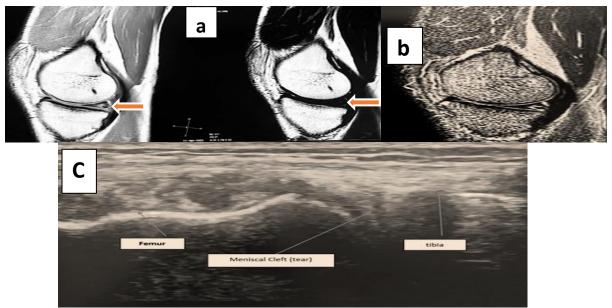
A 23 years Male patient Complain of left knee pain and click with history of trauma since 1 year. MRI exam.: (a) Sagital PDWI and T2WI Showed abnormal signal intensity at posterior horn of medial meniscus reaching to articular surface denoting tear. (b) Sagital STIR Showing branching tear within posterior horn of medial meniscus. Ultrasonsography (c) showing fluid filled gaped (cleft) seen within medial meniscus indicate a meniscus tear.
